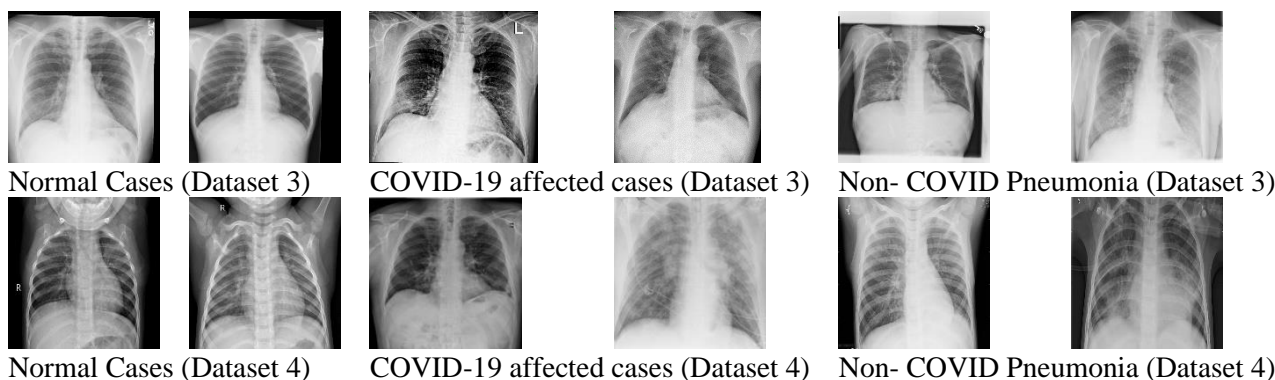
Sample X-ray images from Dataset 3 [18], [36], [37] and Dataset 4 [38], [39]
